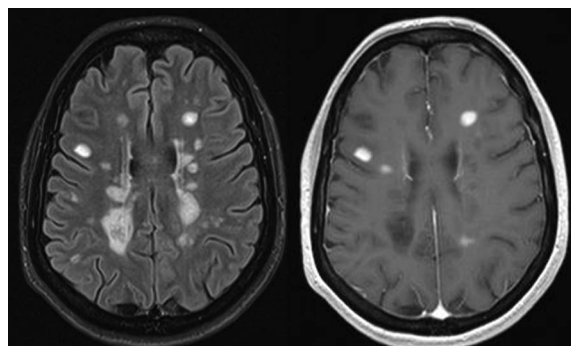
Conventional magnetic resonance imaging in multiple sclerosis. T2-FLAIR (left) and gadolinium-enhanced T1-weighted (right) sequences. T2-FLAIR image shows multiple focal demyelinating lesions that are hyperintense relative to the normal appearing brain tissue. After contrast administration, some of the lesions are hyperintense on T1-weighted images, indicating increased permeability of the blood–brain barrier, a feature that distinguishes acute from chronic demyelinating lesions. FLAIR, fluid attenuation inversion recovery.
